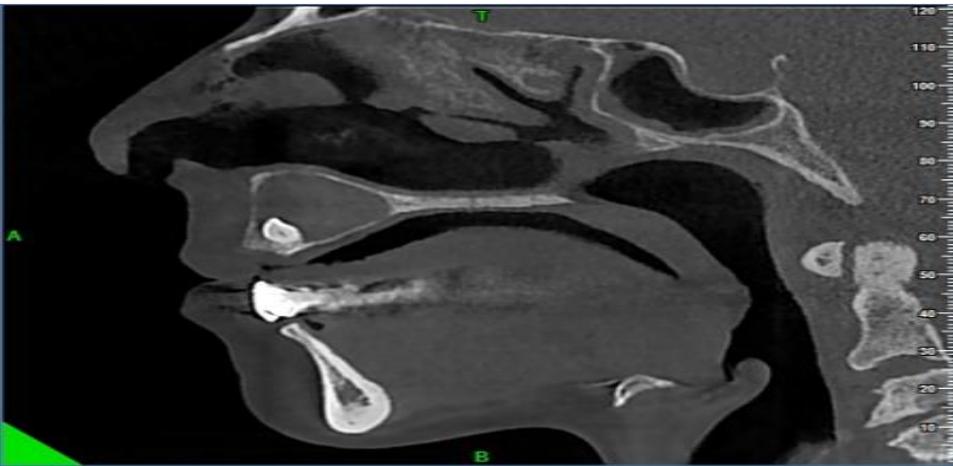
Sagittal view of CBCT showing embedded odontoma into the lesion
